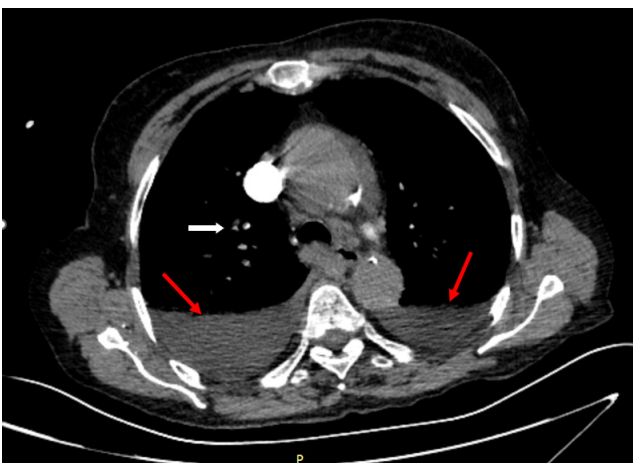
Computed tomography; it was reported as "Filling defect compatible with pulmonary embolism in the segmental branches going to the lower lobe of the right lung and pleural effusion with a thickness of approximately 4 cm on the right and approximately 2 cm on the left bilaterally"
